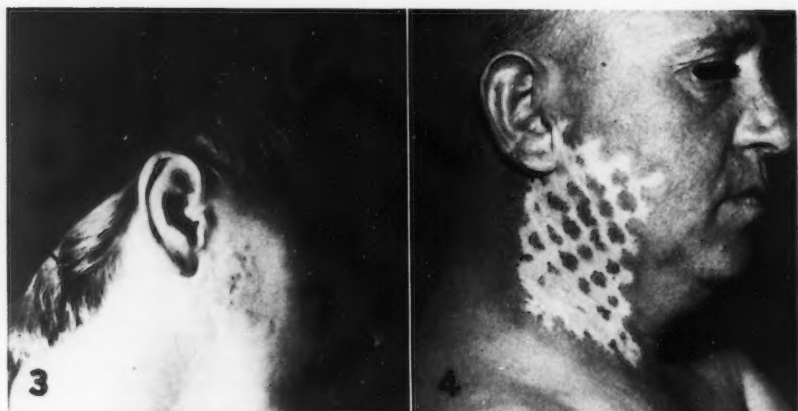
Case 2. Moderate radiation sequelae of skin, seven years after roentgen-ray therapy for recurrent adenocarcinoma of the parotid, Grade III. The skin dose was 7900 r in twenty-three days.
